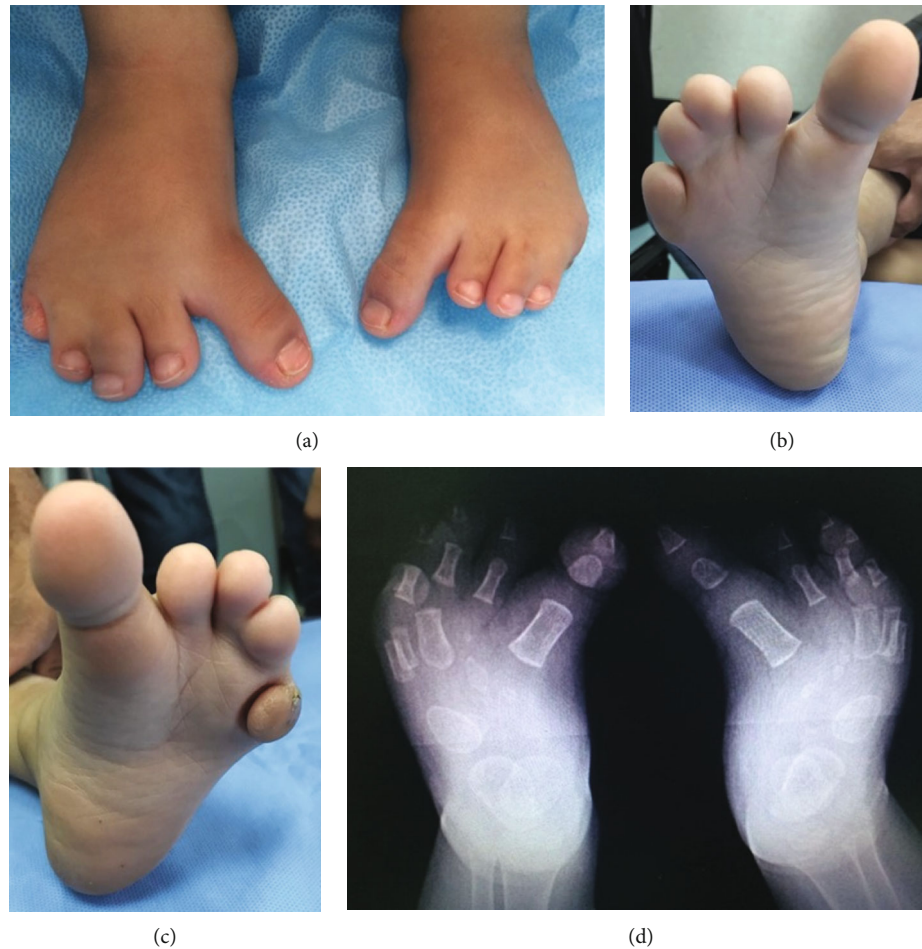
The feet of the homozygous child: (a) note the relatively long and medially deviated big toes. Also, note the plantar flexion deformity of the postaxial four toes; (b) cupping of the forefoot on the right; (c) cupping of the forefoot on the left; (d) X-rays of the feet. Note the metatarsal-to-tarsal transformation.
